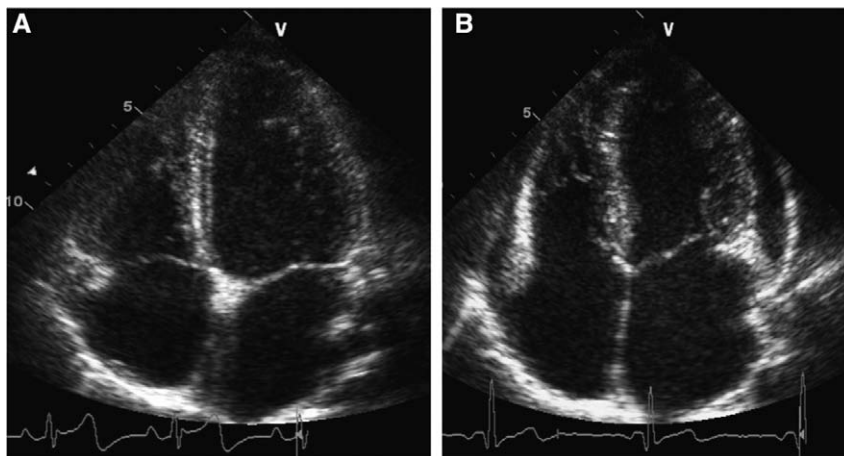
Two-dimensional apical 4-chamber view in a pregnant control (A) and a white patient with preeclampsia aged 30 years at 27 weeks of gestation (B). The case and control are matched for ethnicity, maternal age, and gestational age at assessment. It is possible to appreciate the left ventricle (LV) concentric remodelling and mild pericardial effusion (yellow arrow) in the patient with preeclampsia (B) vs a normal LV geometry in the control (A).
